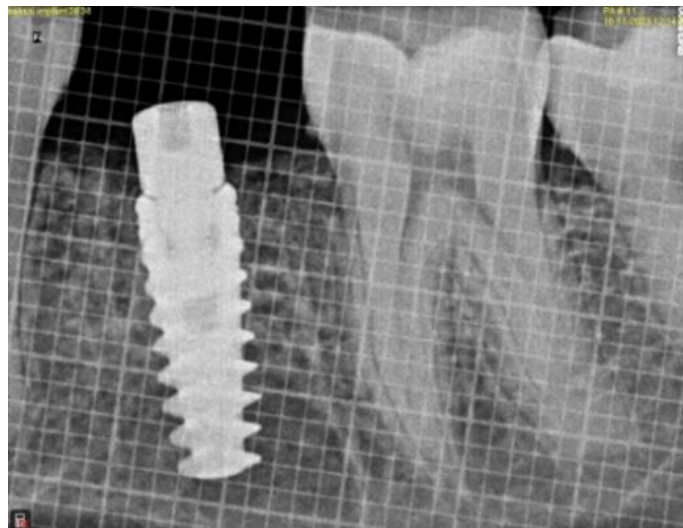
Radiographic finding at 3rd month
